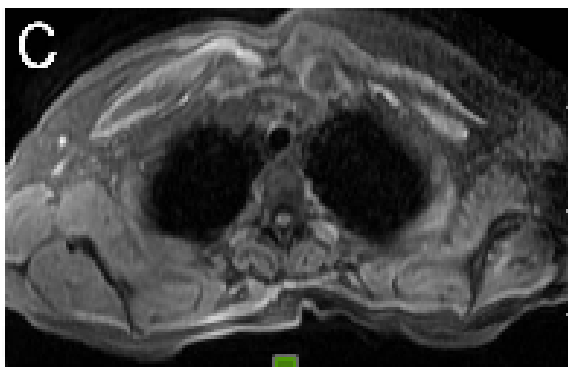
(A,C) Axial T2W image and axial fat saturation T1W image show soft tissue edema and inflammation around left sternoclavicular joint. (B) Soft tissue edema and inflammation around left sternoclavicular joint are seen also axial CT image.
